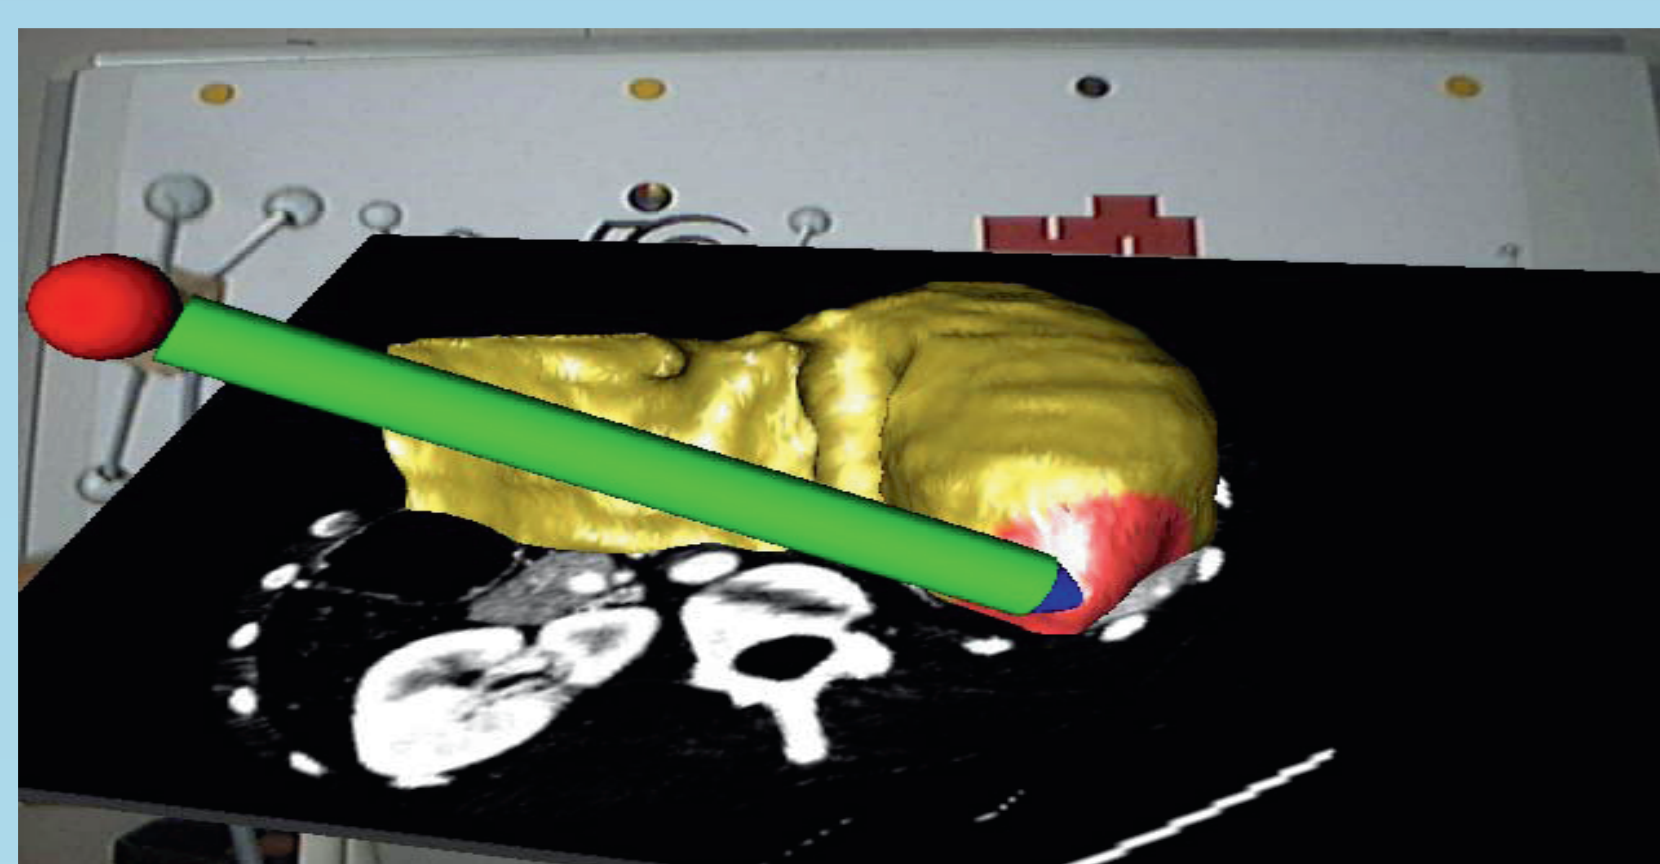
A 3D reconstruction of a liver as well as the pencil, which has activated a part of the liver surface for editing, is shown. The source CT data are displayed as selected by the PIP cutting plane.
